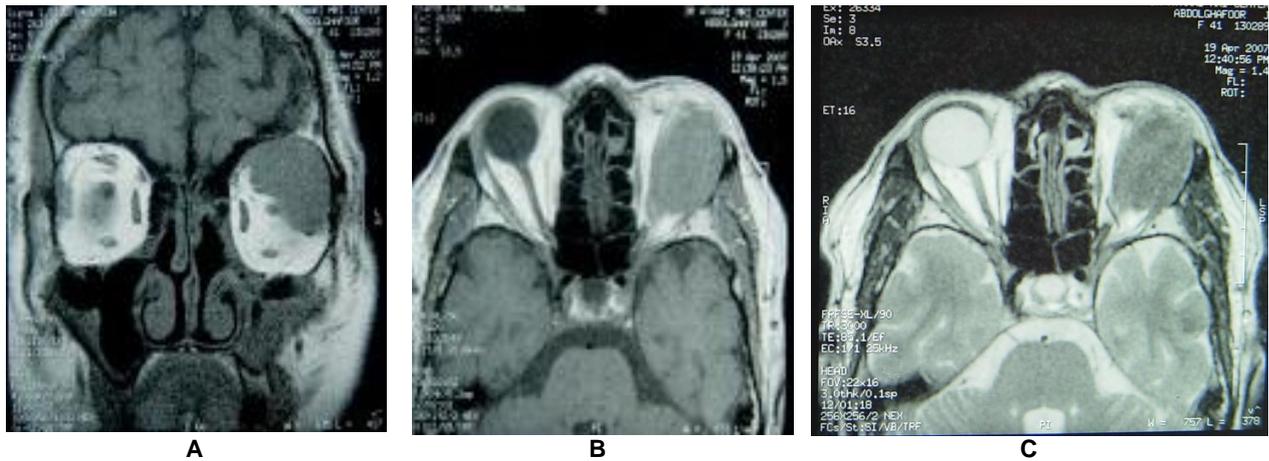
Magnetic resonance imaging scans of the brain in coronal (A) and axial (B, C) projections, showing a homogenous orbital mass with extension to posterior and inferior
